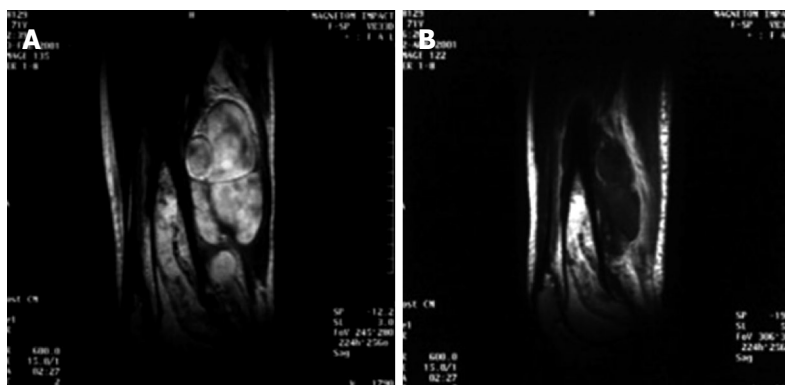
Contrast-enhanced magnetic resonance images (A) before and (B) 14-d after high intensity focused ultrasound ablation in a 45-year-old patient with osteosarcoma at the upper right tibia.
